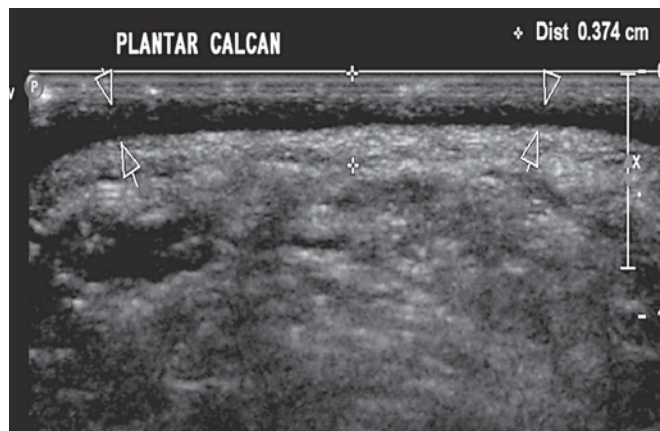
Ultrasound scan performed over the calluses at the proximal plantar foot in a PC patient demonstrates an anechoic layer interposed between the epidermis and the dermis (arrows), representing blisters of fluid below the calluses. The whole skin thickness is 0.374 cm (cursors).
